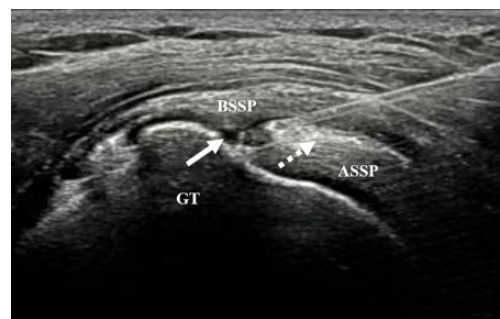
Ultrasonography-guided intratendinous injection. The needle tip is positioned at the intratendinous tear site (solid arrow). The injected atelocollagen spreads into the intratendinous tear gap between the bursal and articular layer of the torn rotator cuff (dotted arrow). ASSP, articular layer of supraspinatus tendon; BSSP, bursal layer of supraspinatus tendon; GT, greater tuberosity.
